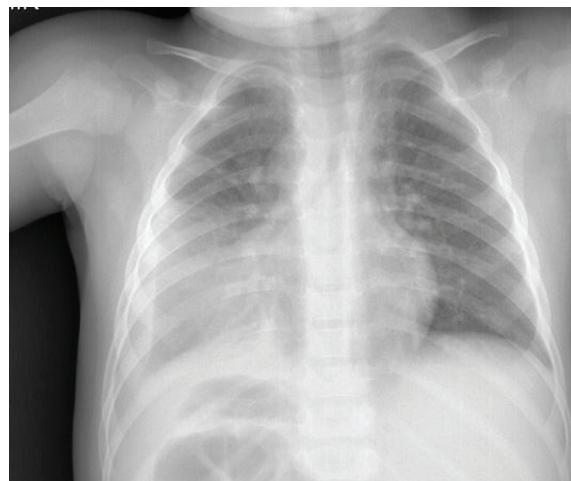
There was an increase in the right opaist on the chest X-ray
